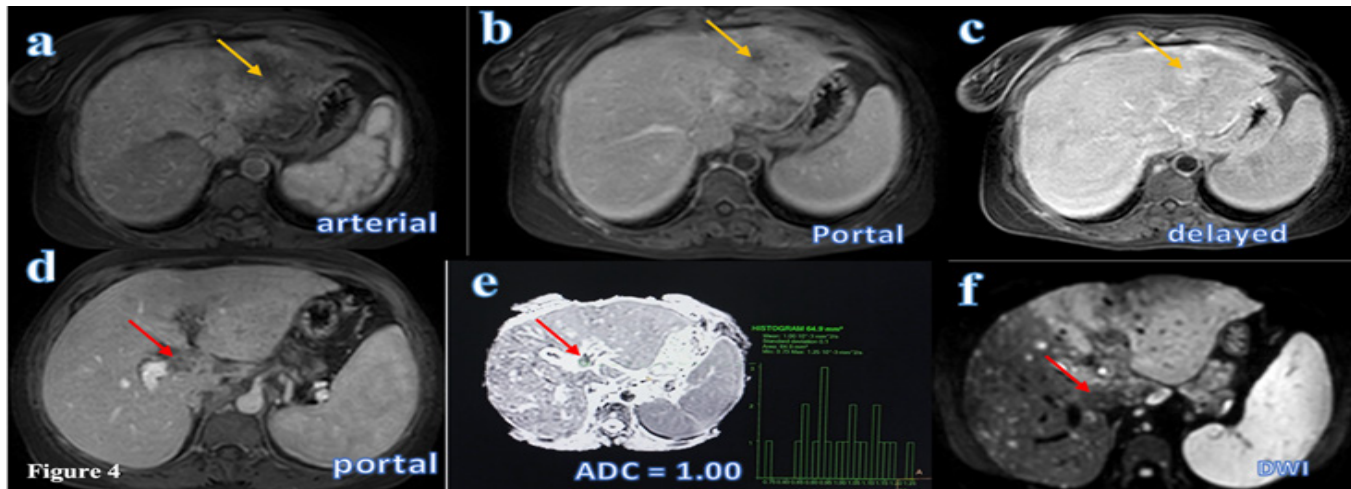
A 72 year-old cirrhotic male patient. (a) Arterial, (b) porto-venous and (C) Delayed images show ill-defined heterogeneously enhancing lesion, keeping with HCC (yellow arrows). (d) Portal phase showing partial left PVT (red arrows). (e) ADC map showing PVT; the ADC value =  $2.0 \times 10^{-3} \text{ mm}^2/\text{s}$  keeping with bland PVT. (f) DWI showing restricted diffusion.
